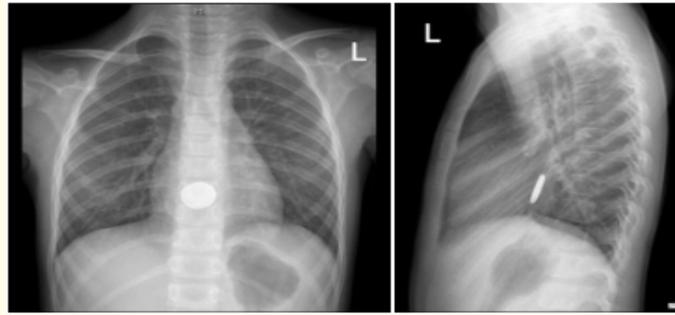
Posterior-anterior and lateral chest x-ray views showing a double-contoured rounded dense structure lodged in the esophagus.
